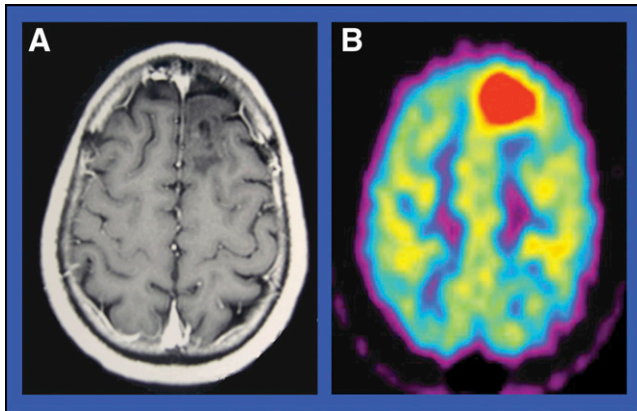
$^{13}\text{N-NH}_3$ PET (B) had a 60% probability of lesion detection compared with only 20% for Gd-DTPA MR imaging (A). This example is in a patient with a grade 3 astrocytoma.
